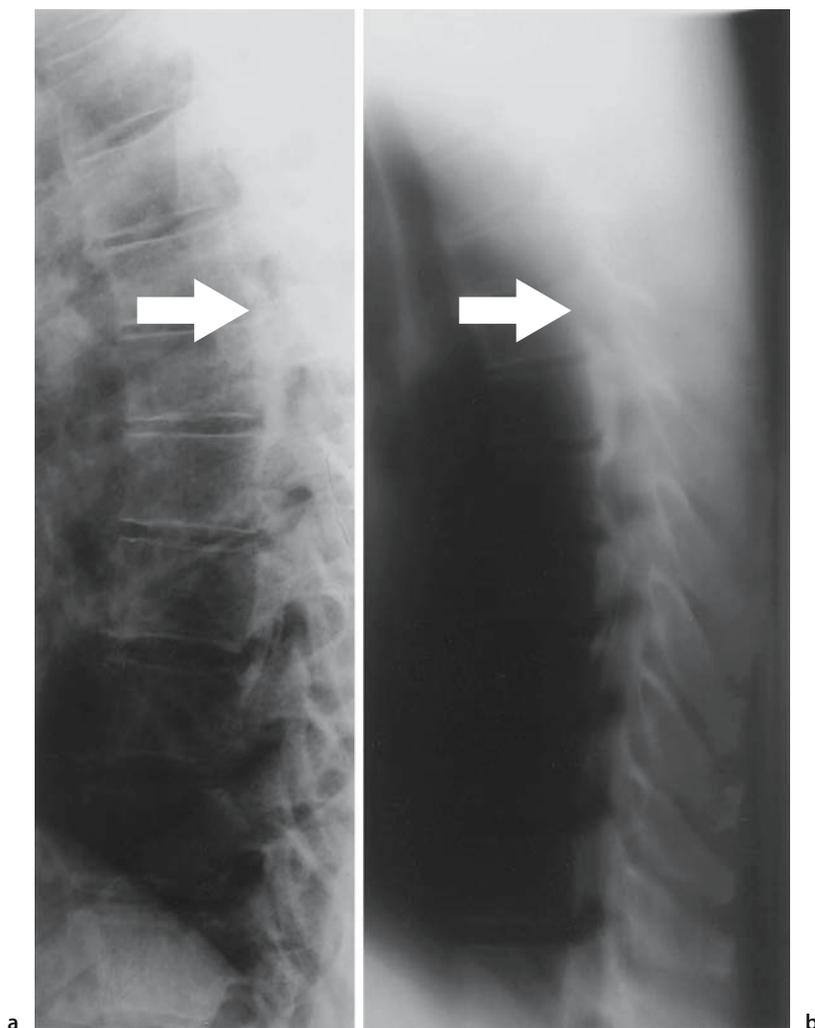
Radiographs of a 45-year-old man with thoracic myelopathy due to ossification of the posterior longitudinal ligament (OPLL). a Posterior border of T6-8 vertebral body cannot be identified by a radiopaque OPLL shadow. b Tomography clearly shows the OPLL. *Arrows, OPLL*
